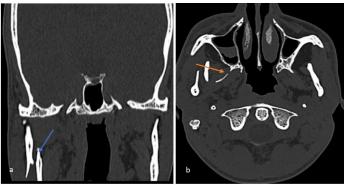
Coronal (a) and axial (b) CT scans in bone window showing a comminuted right low subcondylar fracture (blue arrow) and fractures of the lateral plate of the right pterygoid process (orange arrow)
